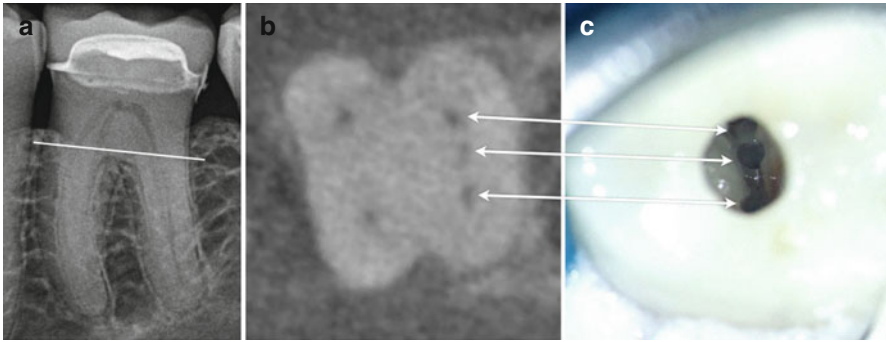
Preoperative periapical radiograph of a mandibular first molar (*white line* represents level of axial CBCT slice) (a). Axial CBCT slice demonstrating three identifiable distal canals (b). Clinical photo demonstrating three instrumented distal canals through a conservative access design in the exact location shown in the preoperative axial CBCT slice (*arrows*) (c)
